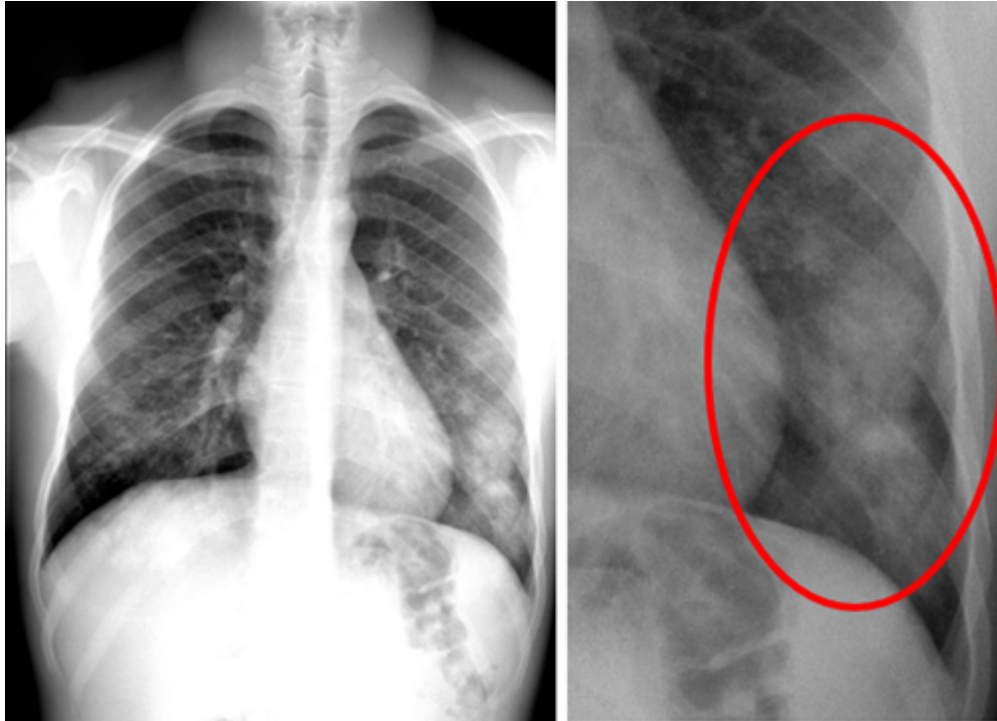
Chest X-ray at admission. [↩](#)
